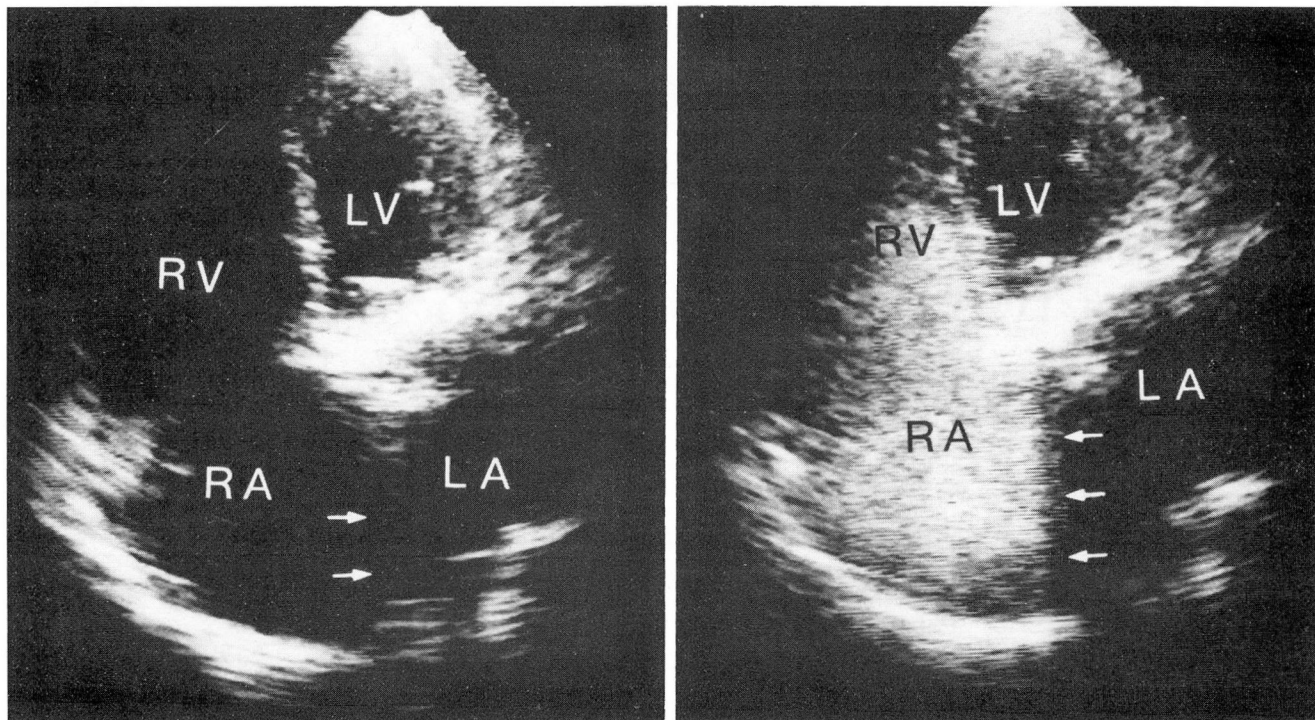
A. Apical four-chamber view in a patient with an enlarged right atrium, demonstrating septal dropout (arrows).
